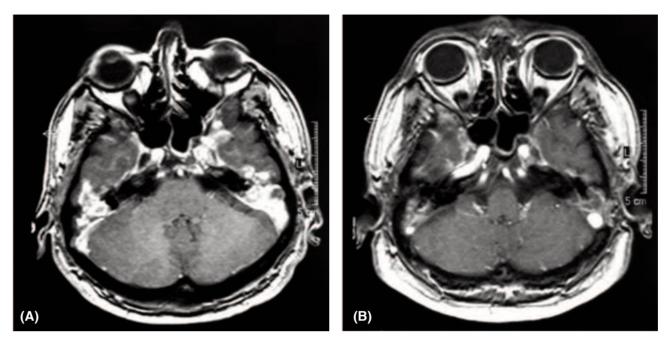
Axial MR imaging of the temporal bone. T1W sequence with Gadolinium. (A) Before biopsy of the mastoid and chemotherapy: An enhanced mass involving the temporal bone is demonstrated, bilaterally. (B) Five months later (following mastoid biopsy and chemotherapy) a decrease in volume and degree of enhancement is appreciated.
